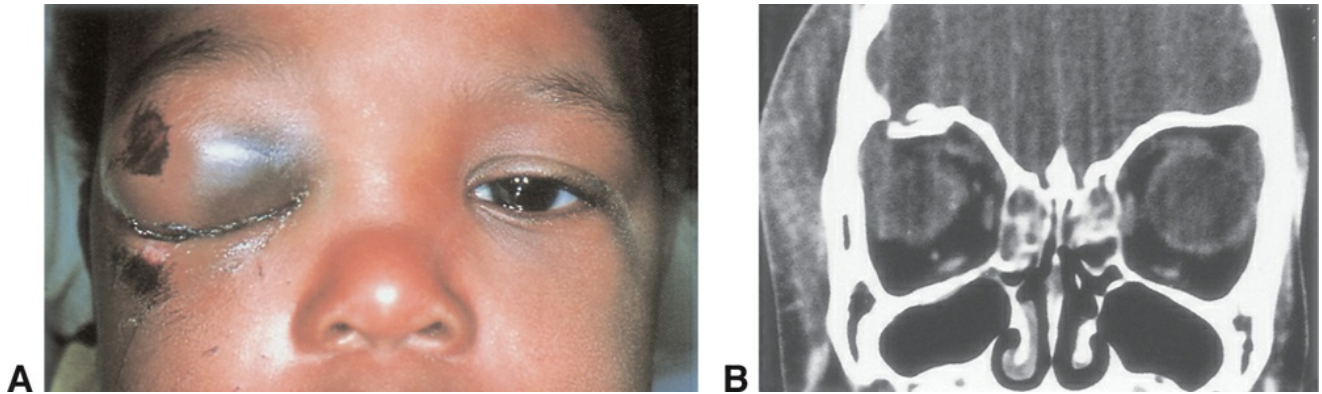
Orbital roof fracture in a child, resulting from direct impact to the brow region in a fall. A, Marked right upper eyelid swelling from a hematoma originating in the superior orbit, adjacent to a linear fracture. B, Coronal computed tomography shows a bone fragment displaced into the right orbit.
